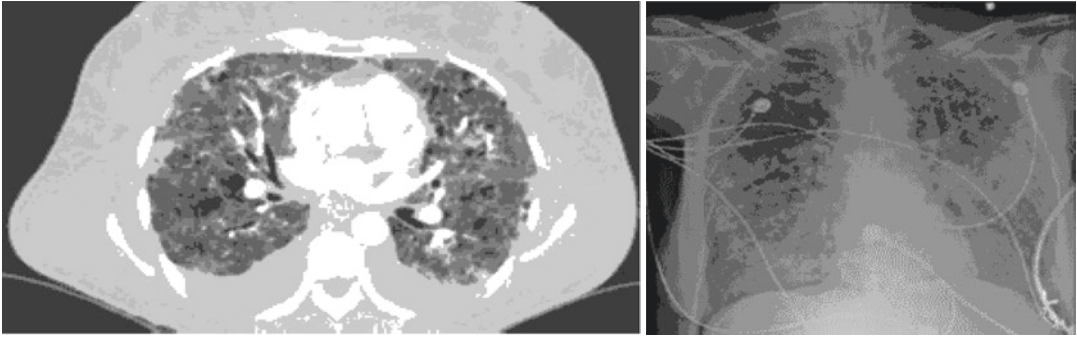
HRCT of the chest showing ground glass infiltrate in AFE
